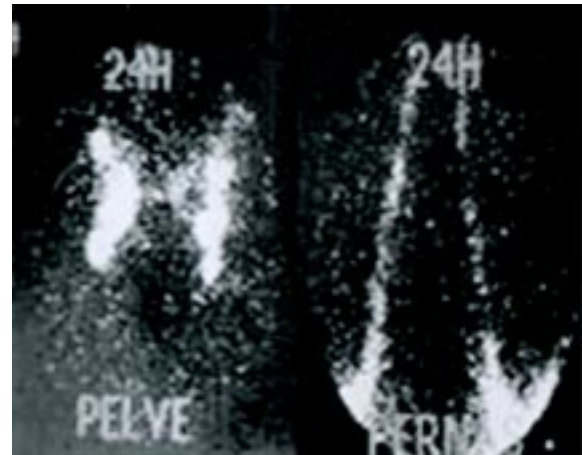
Lymphoscintigraphy showing pelvic (PELVE) and inguinal (PERNAS) stasis after 24 hours.
